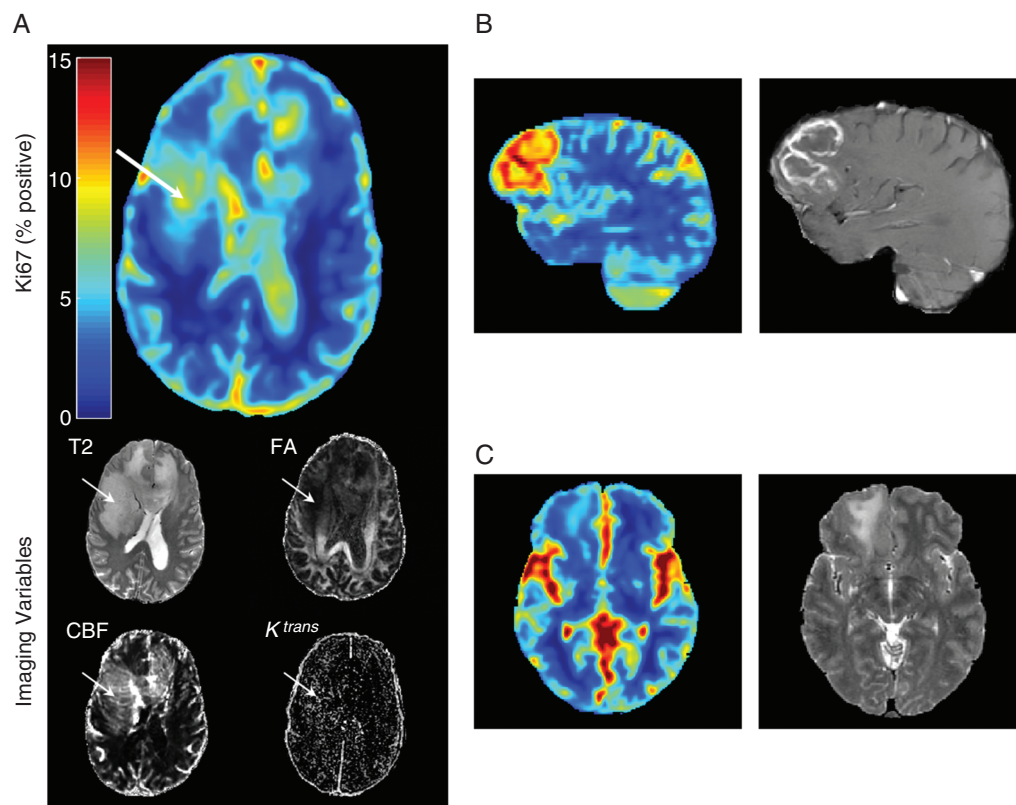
Quantitative maps. Ki-67 map generated using the random forest trained on the 4 imaging inputs shown in axial view: T2-weighted image, FA, K^{trans} transfer constant, and CBF. Areas of increased estimated Ki-67 (white arrow) likely contain more actively dividing tumor cells and provide a better target for biopsy. In tumors like (A), a grade III anaplastic astrocytoma, sampling the most malignant area of the tumor is important for correctly grading the tumor. This tumor did not demonstrate contrast enhancement, which is clinically used for biopsy target selection, when present. (B) for enhancing tumors (glioblastoma multiforme shown), the highest estimated Ki-67 generally corresponds to enhancement (the currently used clinical target for biopsy selection). (C) For low-grade tumors (shown grade II diffuse glioma) the estimated (and measured) Ki-67 is generally low. Seemingly raised Ki-67 values in the sulci and cisterns are artefactual, but are unlikely to confuse an experienced clinician.
